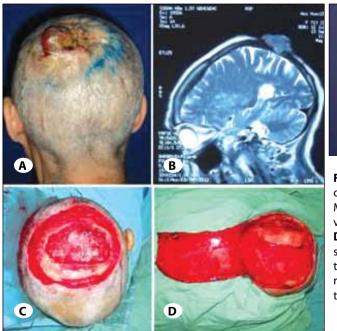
A) Posterior view of a 65-year-old woman with squamous cell cancer at left parietal region. B) Sagittal view of the cranial MRI showing the tumor invading duramater. C) Peroperative view showing a 13x13 cm defect, after removal of the tumor. D) Peroperative view of the large scalp flap based on right superficial temporal artery. E) Postoperative view showing the transposed flap covering the defect and the flap donor site was reconstructed with split thickness skin graft. F) Posterior view of the patient at postoperative sixth month.
